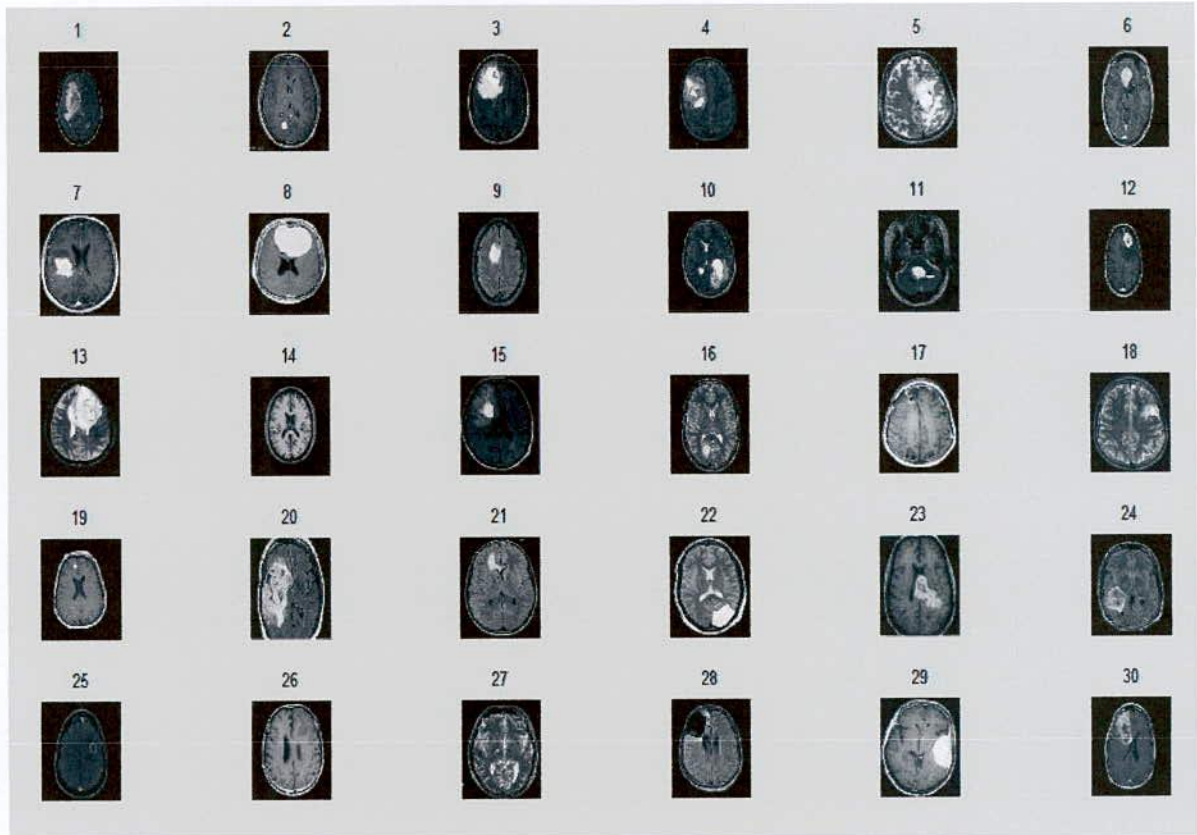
The database of 30 brain tumor MRI image
